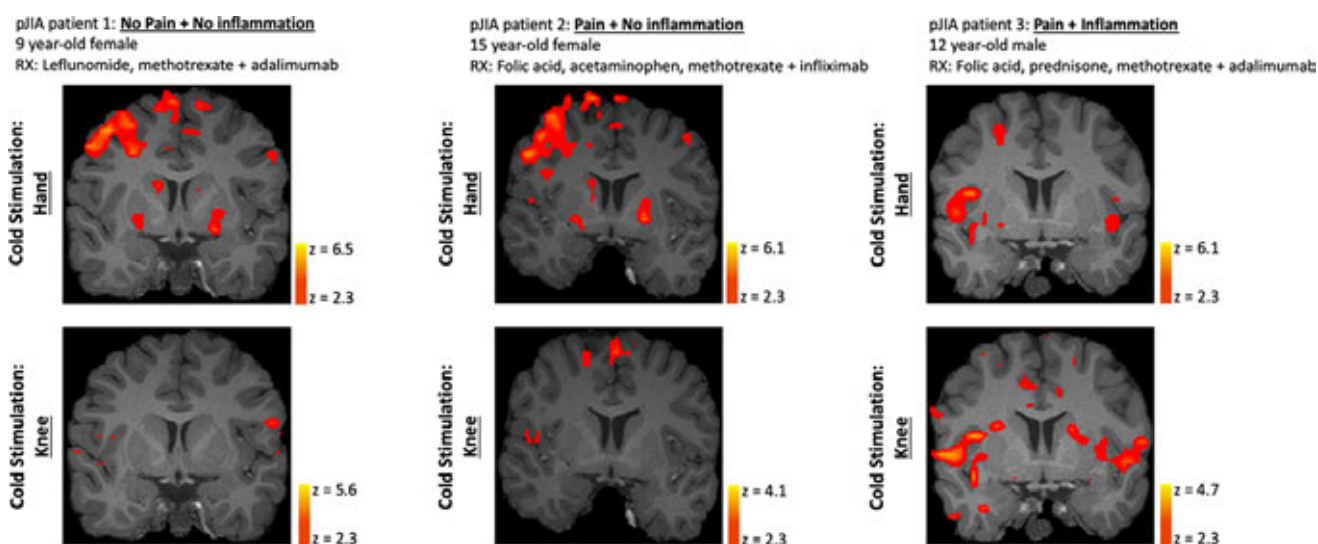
Evoked CNS Response in pJIA Patients With and Without Pain During Unilateral Cold Stimulation of the Hand (Top Row) and Knee (Bottom Row). Overall greater CNS activation was induced by cold stimulation of the dorsal side of the hand compared to the knee. Greater CNS activation for pJIA patient 3 for knee cold stimulation may have resulted from prior knee involvement. This patient reported pain during cold stimulation for both sites (hand and knee). Statistical activation maps are depicted on subject-specific, high-resolution anatomical MRI data.
